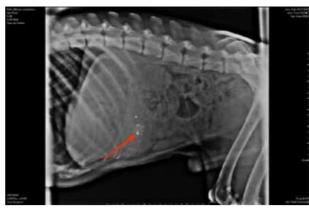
Abdominal radiograph showing metallic opacity (red arrow) in the pyloric region.
